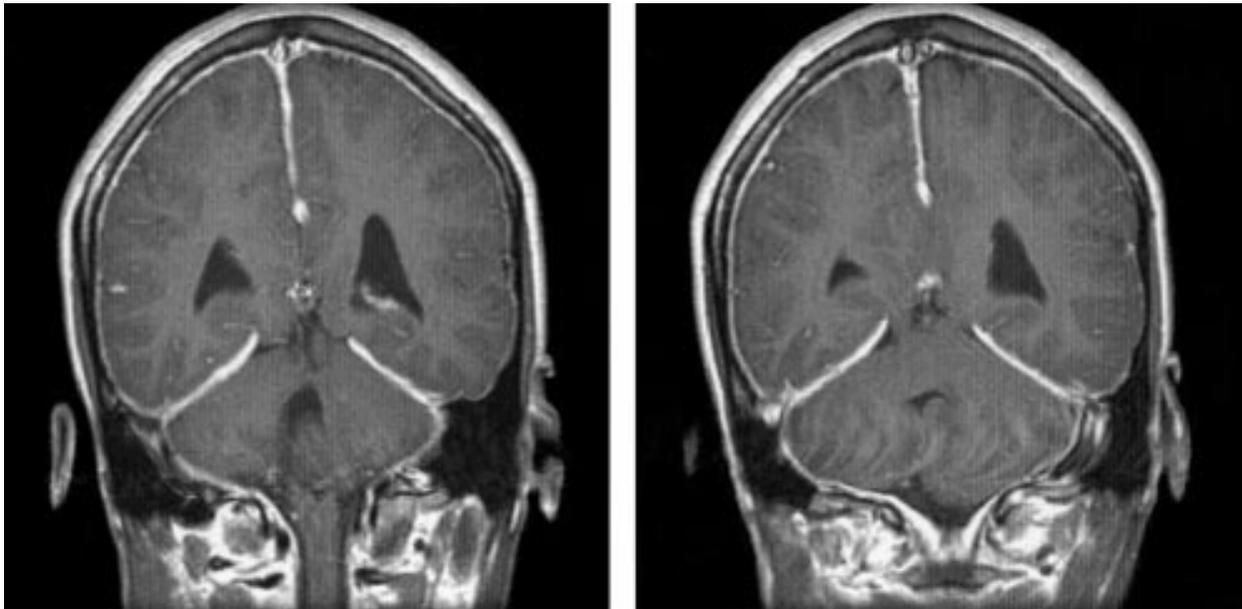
Magnetic resonance image showing diffuse meningeal enhancement after gadolinium administration in a patient with low CSF volume (pressure) headache.
